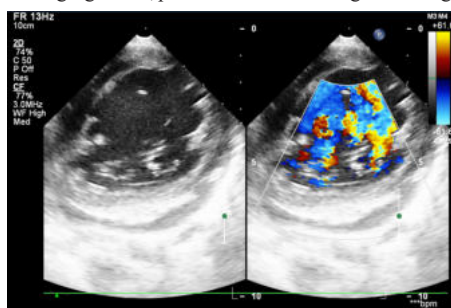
shows short axis view with double orifice mitral valve along with color flow Doppler image at the same plane showing severe mitral regurgitation.
